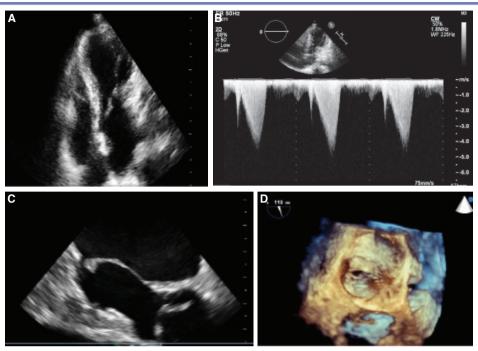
(A) Transthoracic apical four-chamber view showing the protrusion from the left ventricular free wall, which functions like a posterior leaflet. (B) There was a significant gradient in the left ventricular outflow tract at rest. (C) Transesophageal image showing the absence of the posterior leaflet. (D) Three-dimensional transesophageal image with left atrial perspective showing the absence of the posterior leaflet.
